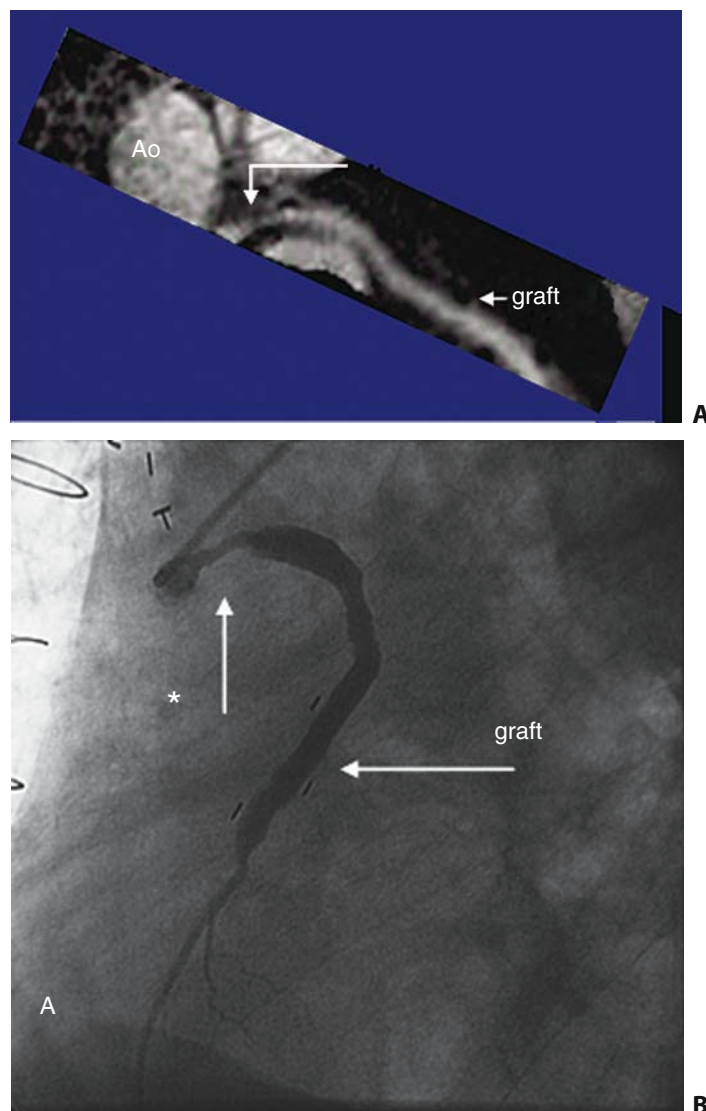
Whole heart coronary MRI reconstruction in a patient with a proximal left anterior descending branch (LAD) stenosis.
